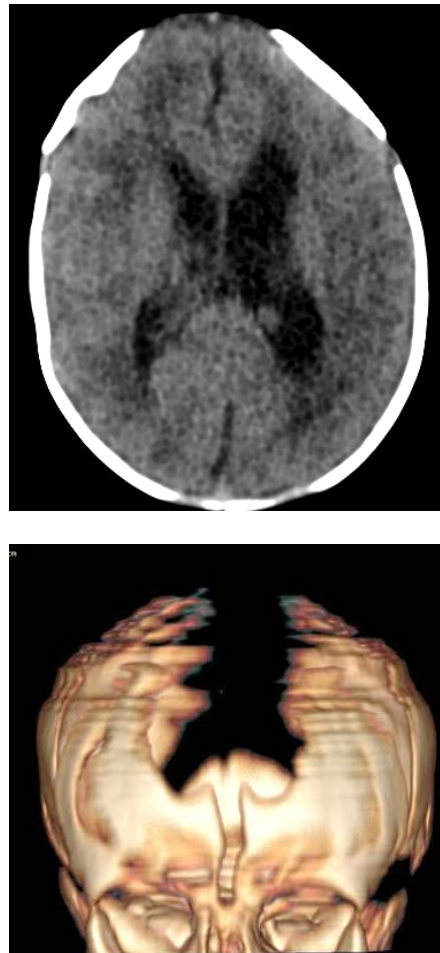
A and B - CT scan showing an abnormal metopic suture
